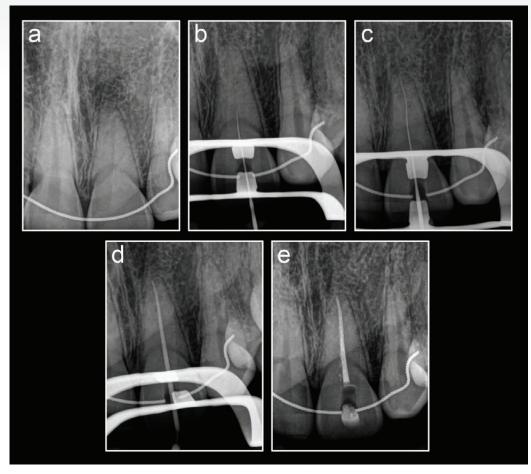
(a) Pre-operative peri-apical radiograph of maxillary left central incisor with obliterated root canal system; (b) Coronal aspect of the root canal negotiated with a 08 C+ File; (c) Length determination peri-apical radiograph; (d) Conefit peri-apical radiograph confirming the fit of a TruNatomy Prime gutta percha point; (e) Postoperative peri-apical radiograph after root canal obturation
